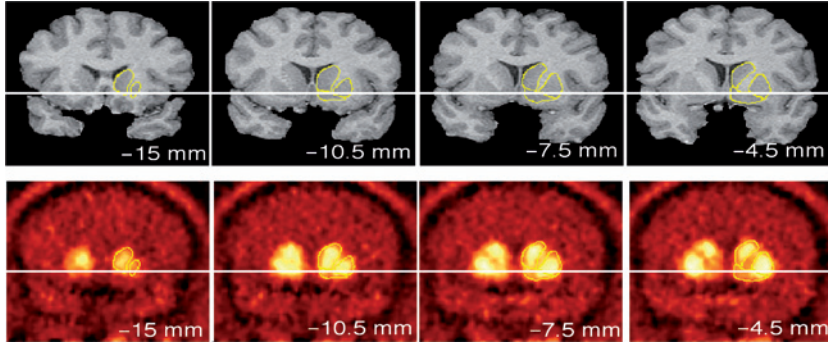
D2 receptor-binding image with PET and [^{11}C]raclopride. MRI images (above) and PET images (below).
